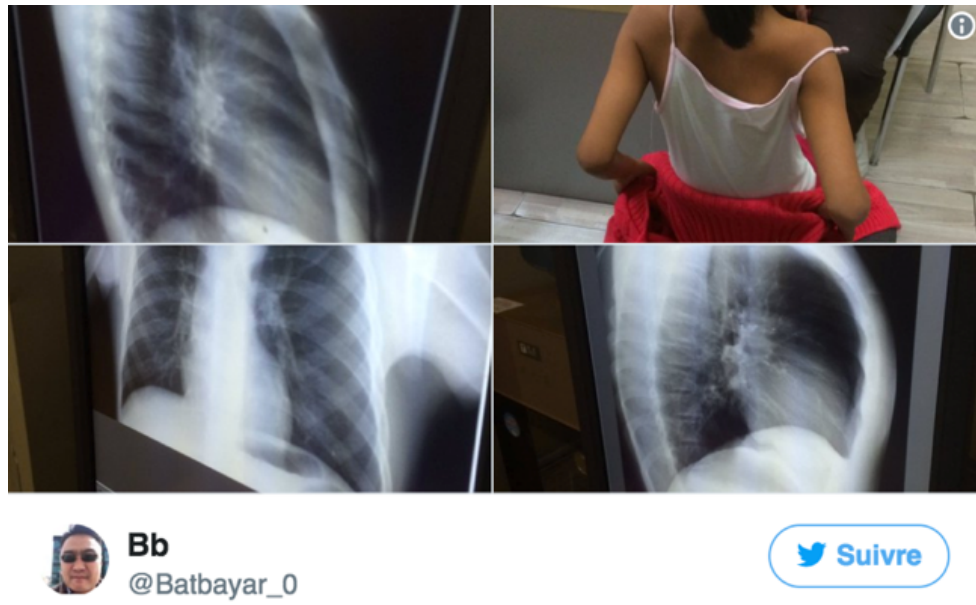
A Twitter post of a young girl's infected chest X-ray
